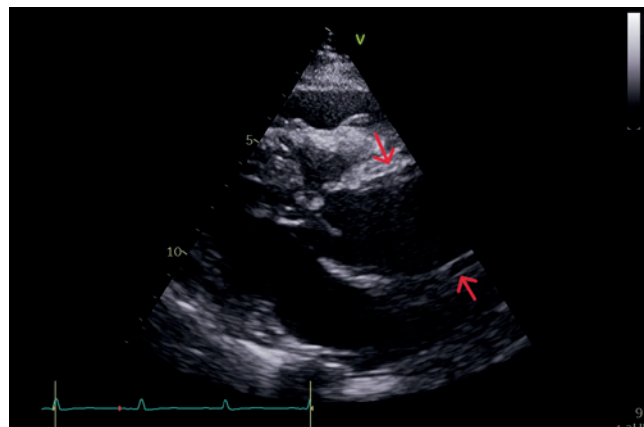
Parasternal long axis showing the abnormal appearance of the aortic walls
